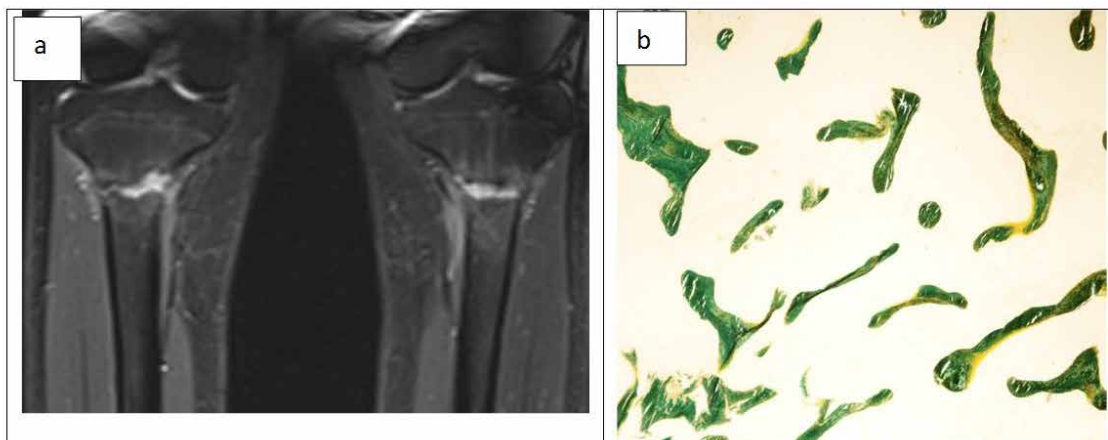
MRI of the calves of the patient showed increased signal at linear T1RM sequence which suggest fluid clefts at both fracture sites
